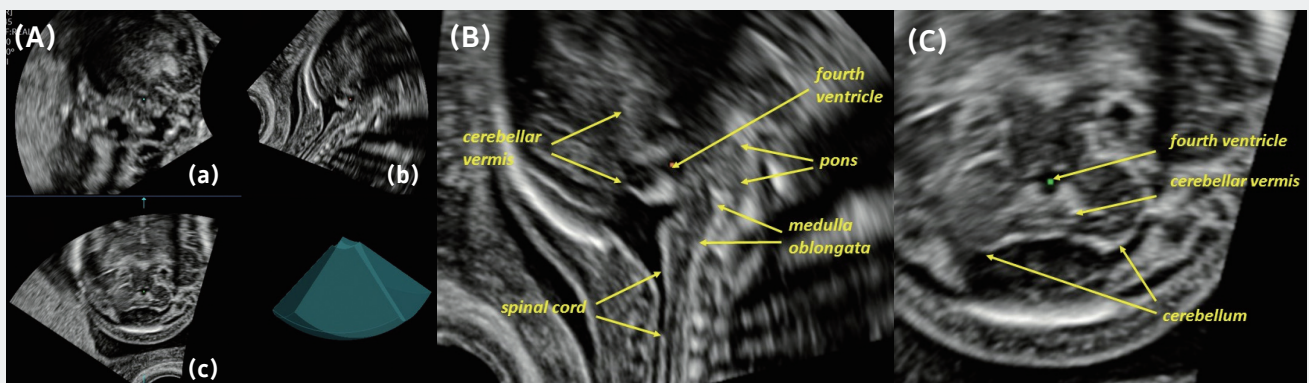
Three-dimensional, multiplanar imaging of the posterior fossa obtained by transvaginal ultrasound through suboccipital insonation on the midsagittal plane. (A) Grayscale, multiplanar view of the coronal (a), sagittal (b), and axial (c) views. (B) Midsagittal view showing highly-defined imaging of the cerebellar vermis, the fourth ventricle, the pons, the medulla oblongata and the proximal cervical spine. (C) Axial view showing the fourth ventricle, the cerebellar vermis, and hemispheres.
